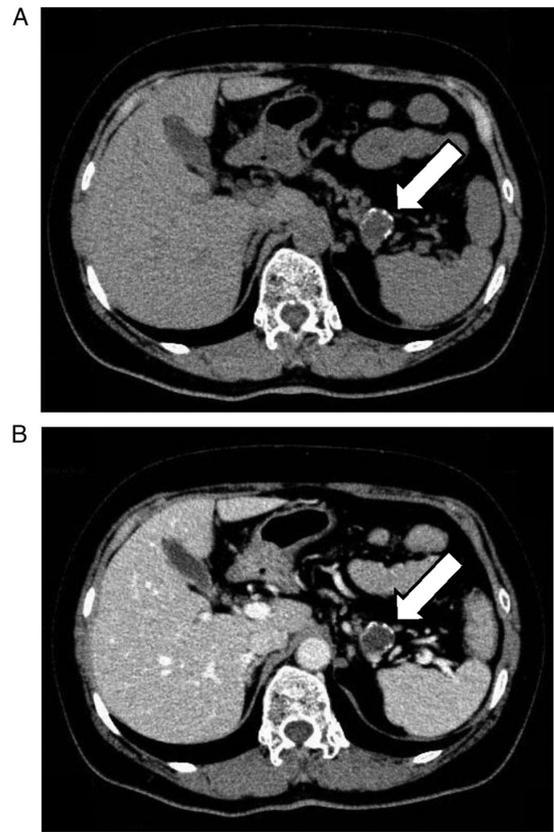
Abdominal plain (A) and contrast-enhanced (B) computed tomography. A cystic lesion in the pancreatic tail with calcification (white arrows).
